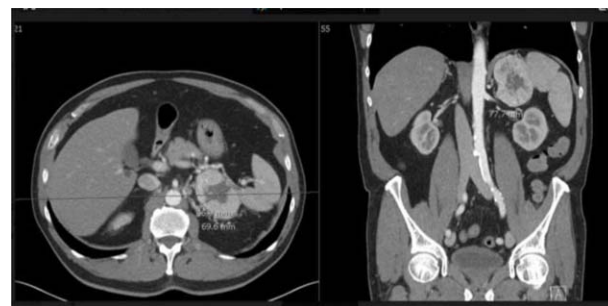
CT imaging showing a heterogeneous mass (> 10 HU) in the left adrenal gland with regular borders, central necrosis, a calcification and strong vascularization
